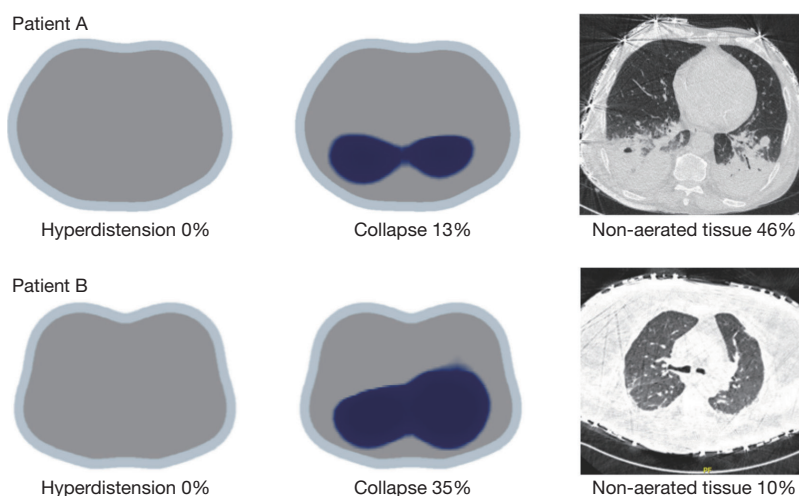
Simultaneous acquisitions of computed tomography (CT) and electrical impedance tomography (EIT) images (Enlight, Timpel, Sao Paulo, Brazil) at positive end-expiratory pressure (PEEP) 5 cmH₂O, after performing a recruitment maneuver and PEEP decremental trial. Patient A has 13% of collapse, but 46% of non-aerated region, while Patient B (morbidly obese) has 35% of collapse, but only 10% of non-aerated region. In both cases, overdistension was 0% at PEEP 5 cmH₂O. Effectively, in the Patient A when comparing the CT at PEEP 5 cmH₂O with CT images taken at 45 cmH₂O (not shown), we observed a percentage of potentially recruitable lung of 12%. In the other hand, Patient B could be related to “silent spaces”, which is only found using EIT monitoring or transpulmonary pressure at end expiration. Project FONDECYT 1161510. Cornejo *et al.*
